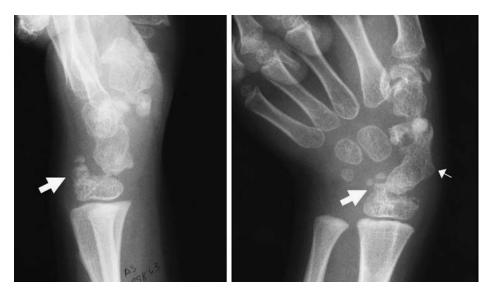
Anteroposterior and lateral radiographs of a child's wrist demonstrating multiple enchondromatous lesions, including pedunculated (thick arrow) and sessile (small arrow) forms.
